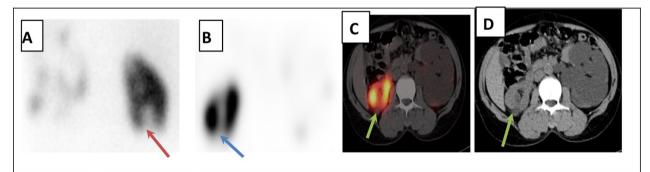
A 50-year-old, female patient, presented with left loin pain. A ^{99m}Tc-DMSA planar image (posterior view) demonstrating defect at the lower pole of the right kidney (red arrow) and hardly visualized left one, B axial SPECT image revealed right lower cortical defect (blue arrow) and non functioning left kidney, C the corresponding fused SPECT/CT and D the CT images shows that the defect is corresponding to small exophytic right cortical cyst (yellow arrows) as well as hydronephrotic left kidney
